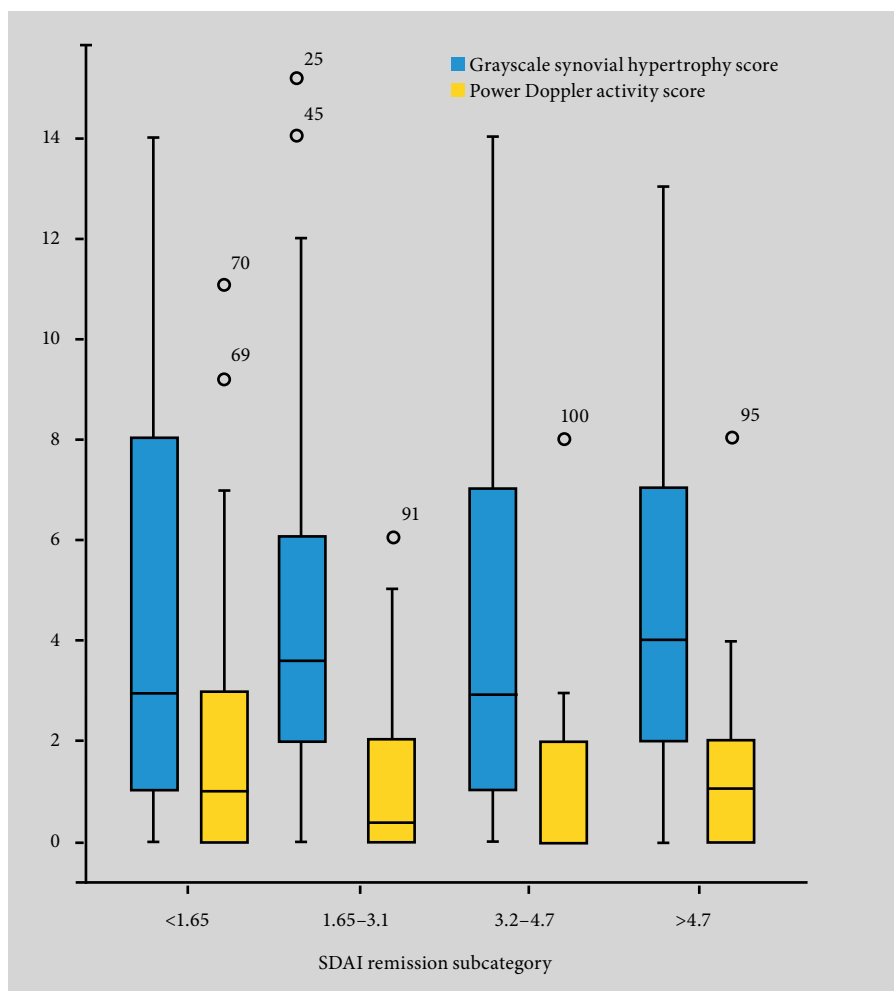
The relationship between stringent Simplified Disease Activity Index subcategories of remission and total median power Doppler activity and total median grayscale synovial hypertrophy score per patients as detected by ultrasound. No significant difference was seen between the groups. SDAI, Simplified Disease Activity Index. Reproduced with permission from Saleem et al [28] ©BMJ.
